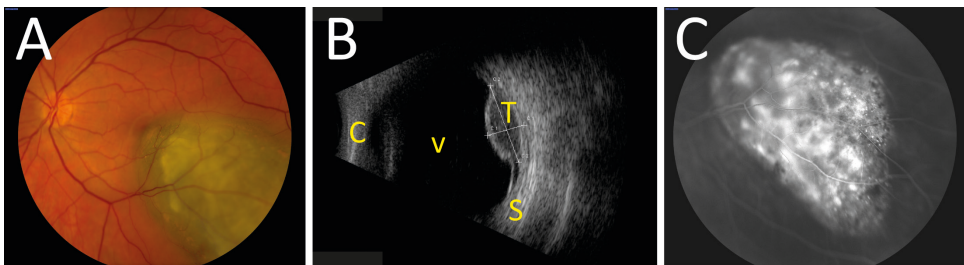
Clinical presentation of choroidal melanoma. (A) Pigmented lesion of the choroid, located in the posterior pole. (B) Ultrasound image of the same patient as in A. Note the dome-shaped configuration and internal 'dark' or 'low' reflectivity of the tumour lesion. (C) Fluorescein angiography of the same patient as in A. Note the vascular pattern and 'pinpoint leakage' of the lesion, which is indicative for melanoma.
